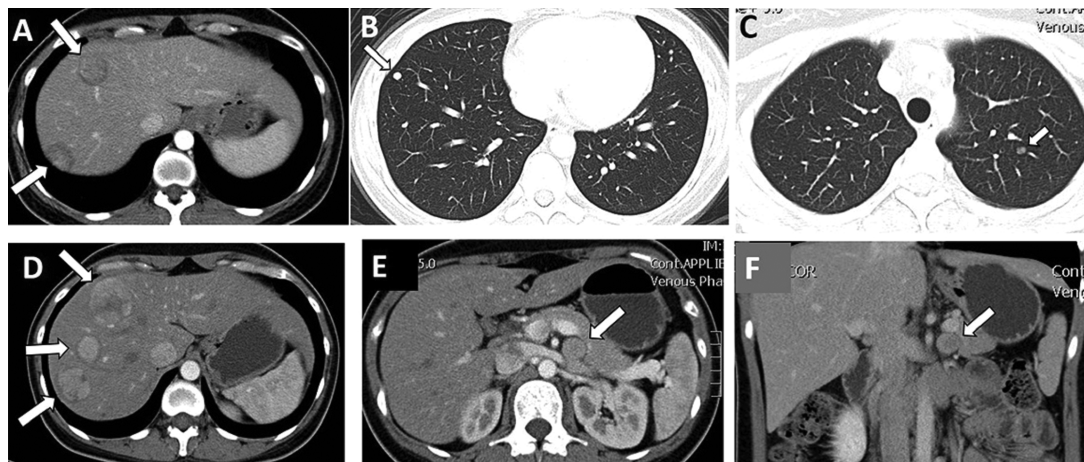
A computed tomography (CT) scan 9 months after the operation showed multiple newly identified metastases in the liver (A) and lungs (B,C). A CT scan after 4 months of systemic chemotherapy and mitotane treatment revealed progression of the liver metastases (D) and a recurrent retroperitoneal adrenocortical carcinoma (E,F).
